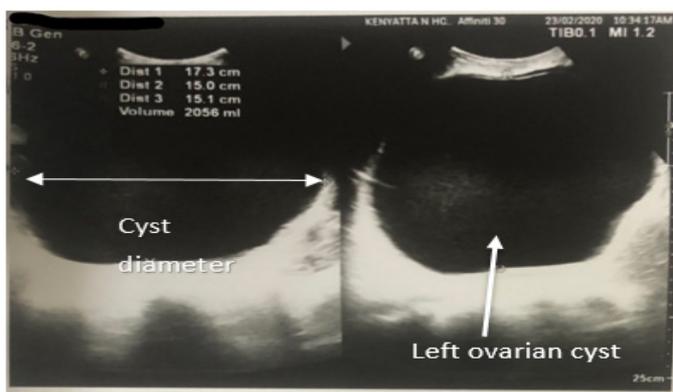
Abdominal ultrasound showing a left ovarian cyst
